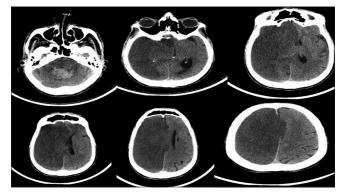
Computed tomography brain showing massive right internal carotid artery territory infarct
